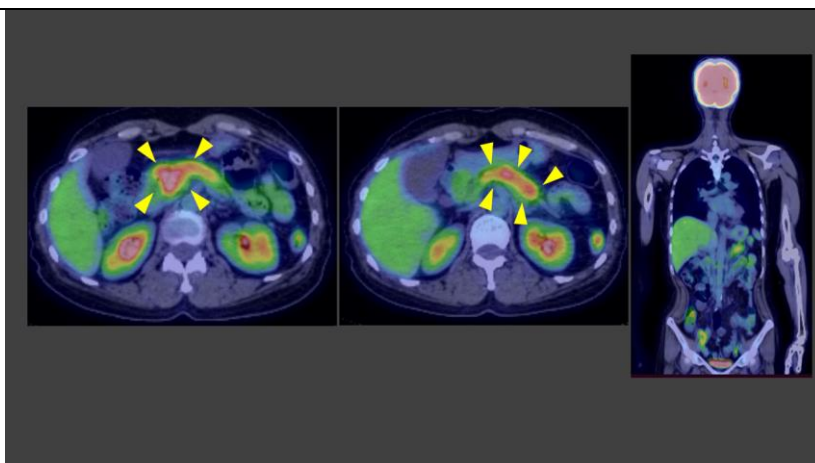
Positron emission tomography computed tomography showed fluorodeoxyglucose accumulation with SUVmax=8.92 in the whole pancreas (arrowheads), whereas no obvious abnormal accumulation in other organs including the hilar lymph nodes.
